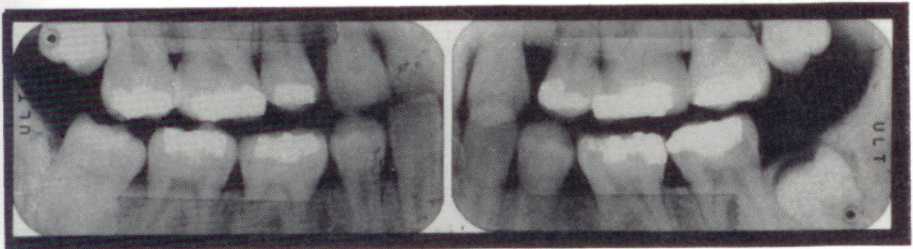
Postmortem dental radiographs of the jaws of victim 9/91. Note that the maxillary 1st premolars (14 and 24) and the mandibular 2nd premolars (35 and 45) are absent.
